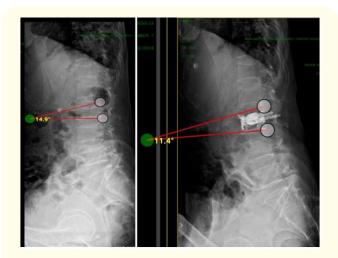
X-rays showing pre and post op change in anterior wedge collapse angle in case of Stentoplasty.
